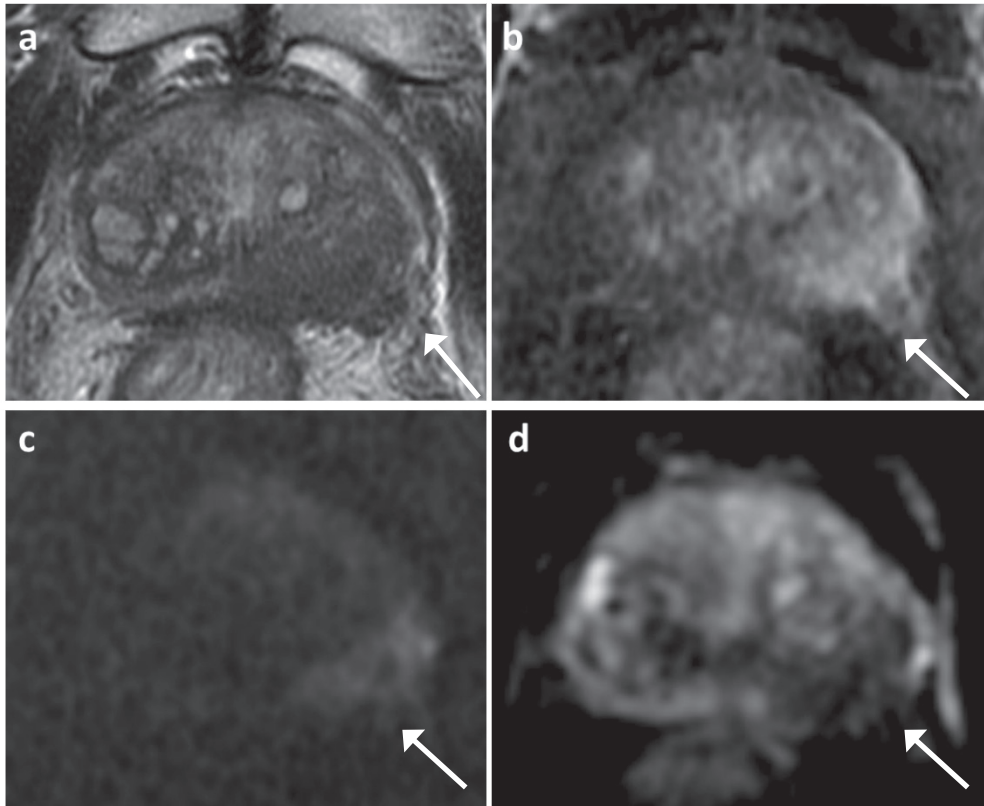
High-quality MRI. (a) T2WI, left peripheral zone posteromedial/lateral lesion. (b) at the same level focal enhancement on DCE MRI. (c-d) at the same level hyperintensity on DWI ($b=2000$) and corresponding hypointensity on ADC map. The lesion was classified as PI-RADS 5 (arrow). T2WI, T2-weighted image; DCE, Dynamic Contrast-Enhanced; DWI, Diffusion-weighted image; ADC, Apparent diffusion coefficient.
